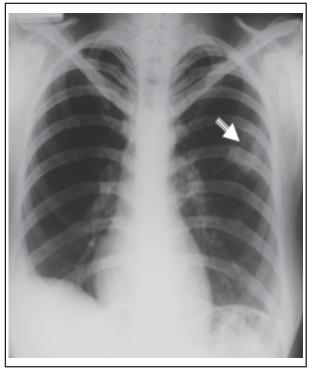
Chest x-ray demonstrating cavitary lesion at the left middle zone and blunted right costovertebral angle.
